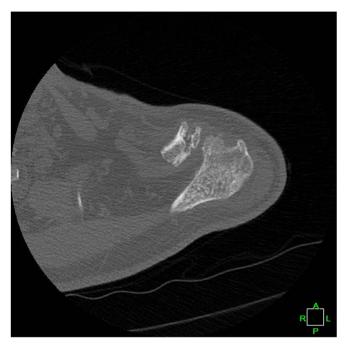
Axial CT scan cut at 8 weeks shows a possible linear osteolucency through the acromion. *CT*, computed tomography.
